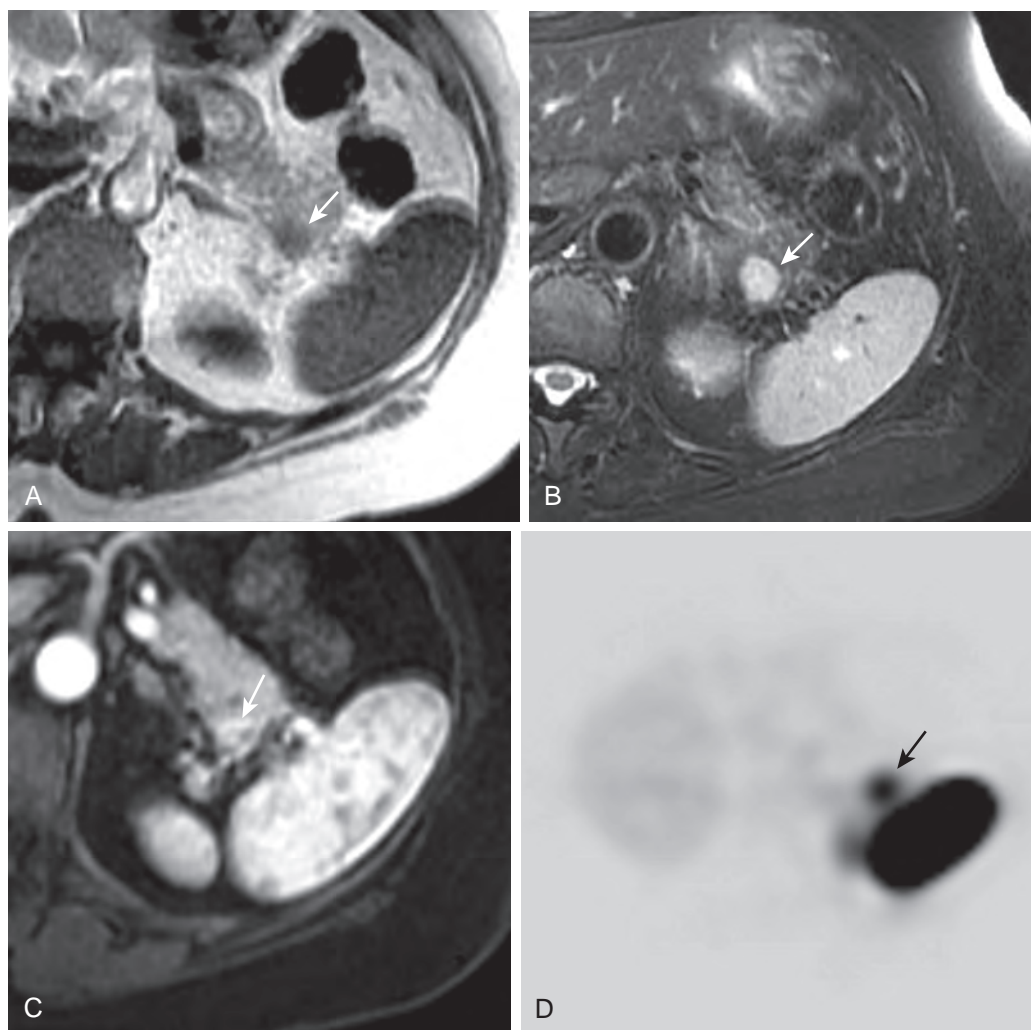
Intrapancreatic accessory spleen: MRI findings and ^{99m}Tc -HDRBC SPECT. A. T1-weighted axial MRI shows an intrapancreatic tail mass (arrow) that is hypointense to pancreas and mildly hypointense to spleen. B. T2 fat-saturated MRI shows the intrapancreatic mass (arrow) to be hyperintense to pancreas but isointense to spleen. C. Gadolinium-enhanced fat-saturated T1-weighted fast spoiled gradient recalled MRI shows the pancreatic tail mass (arrow) to have arterial enhancement similar to that of spleen. D. ^{99m}Tc -HDRBC SPECT shows focal uptake (arrow) near the splenic hilum in the region of the tail of the pancreas.
